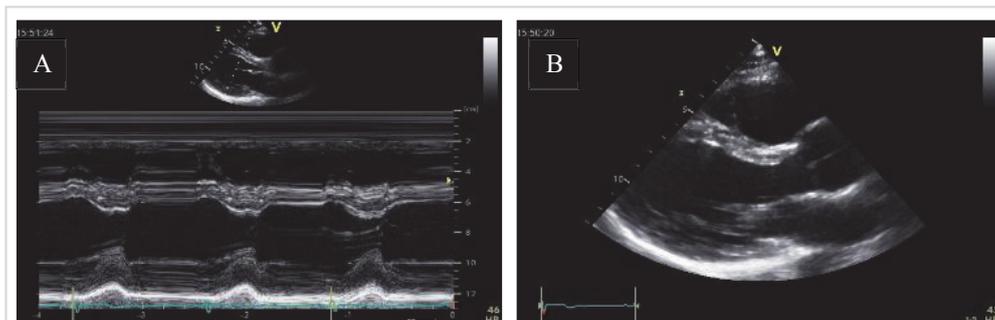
A: M-mode image, left ventricle. B: B-mode image of the left ventricle, parasternal long axis view.
